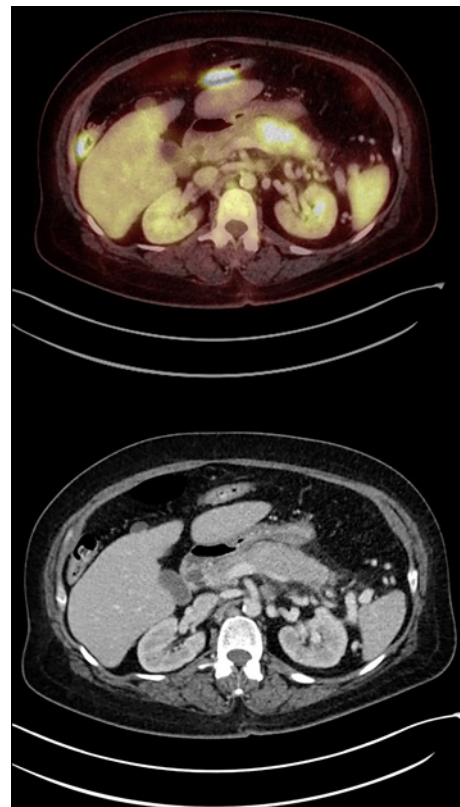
CT and positron emission tomography scan showing pancreatic adenocarcinoma.
